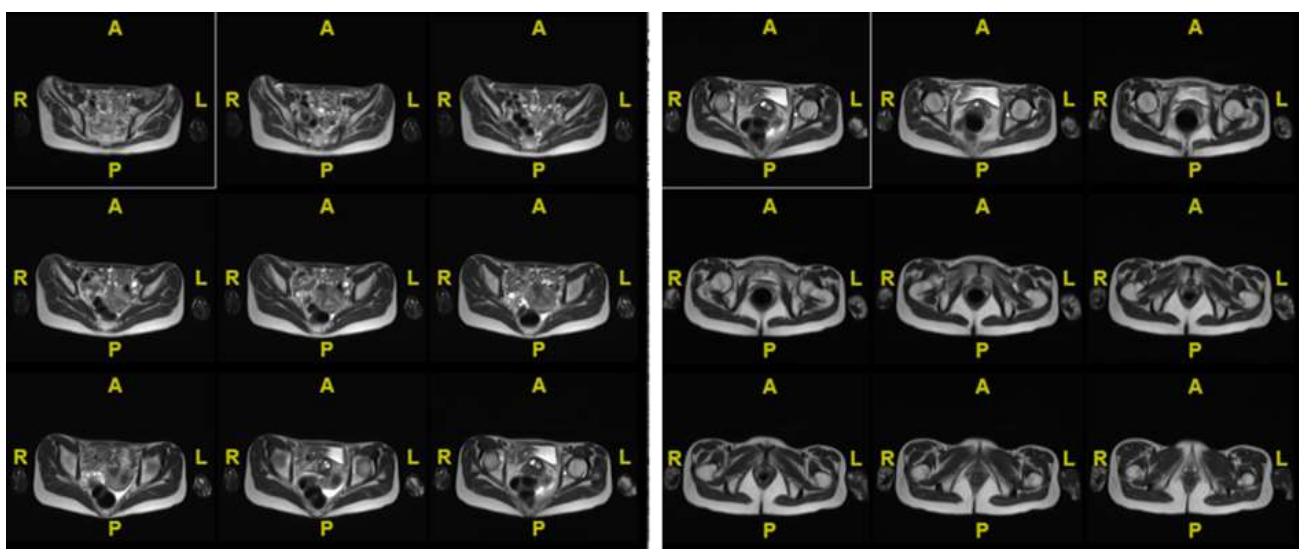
Results of MRI examination with contrast in the pelvis.
